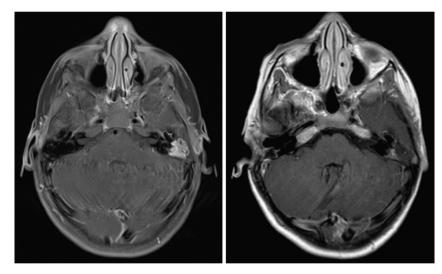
(Left) MRI T1 post contrast axial cut of our patient at her initial diagnosis of LCH. Note the hyperintesnity in her left temporal bone. Both cholesteatoma and LCH are iso/hyperintense on T2 and hypointense on T1.8 However, only LCH enhances with contrast. (Right) MRI T1 post contrast axial cut of our patient 10 months after her right-sided mastoidectomy: cholesteatoma is now seen as the hypointense mass in the left EAC.
